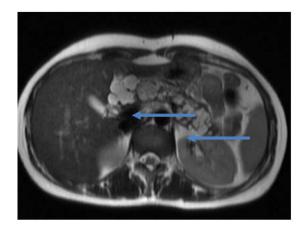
Axial T2 MRI image showing extensive hyperintense cysts replacing pancreatic parenchyma (arrows)
